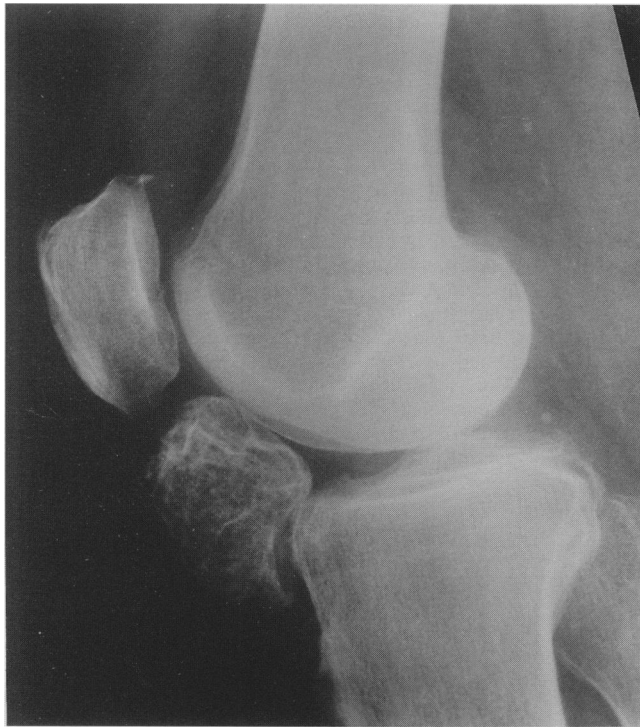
Plain radiograph of synovial chondroma in the knee (case 4).
